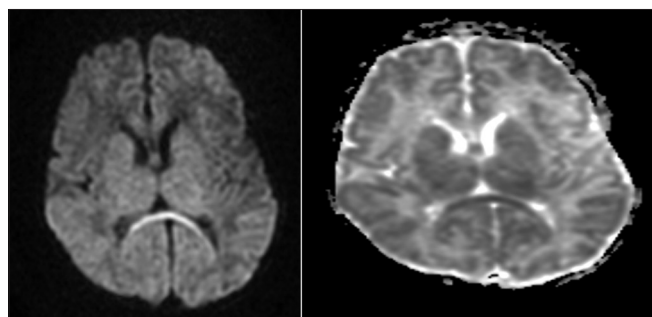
Magnetic resonance imaging in 8-day full-term female with a neonatal hypoxic injury. Axial T1-weighted image shows abnormally increased signal intensity in bilateral basal ganglia, thalamus, and perirolandic cortex. In addition, there is the absence of normal bright signal in the posterior limb of internal capsule, referred to as “absent posterior limb sign.” Axial diffusion-weighted images show hyperintense signal in bilateral basal ganglia, thalamus, perirolandic cortex, bilateral parietal lobes, genu, body and splenium of corpus callosum. Apparent diffusion coefficient maps show hypointense signal in same structures confirming that abnormal signal intensity is due to restricted diffusion
